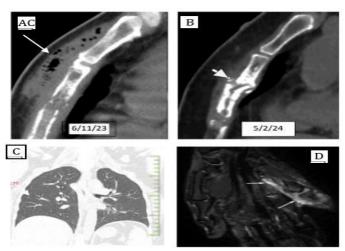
A and B. Sternal osteomyelitis, C. CT thorax, D. Hand osteomyelitis
